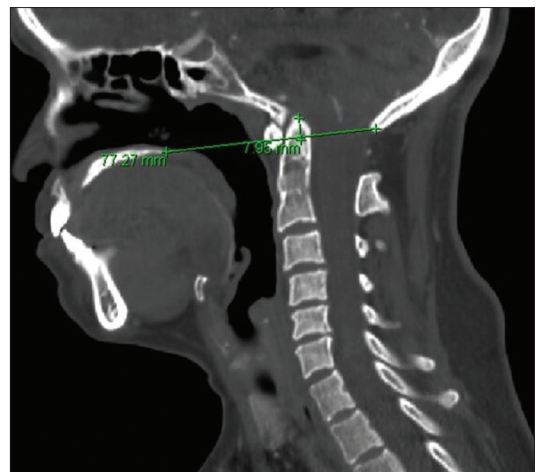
Preoperative lateral CT scan of the cervical spine with 12 lbs of traction demonstrating ~2-mm of reduction when compared to Chamberlain line.
